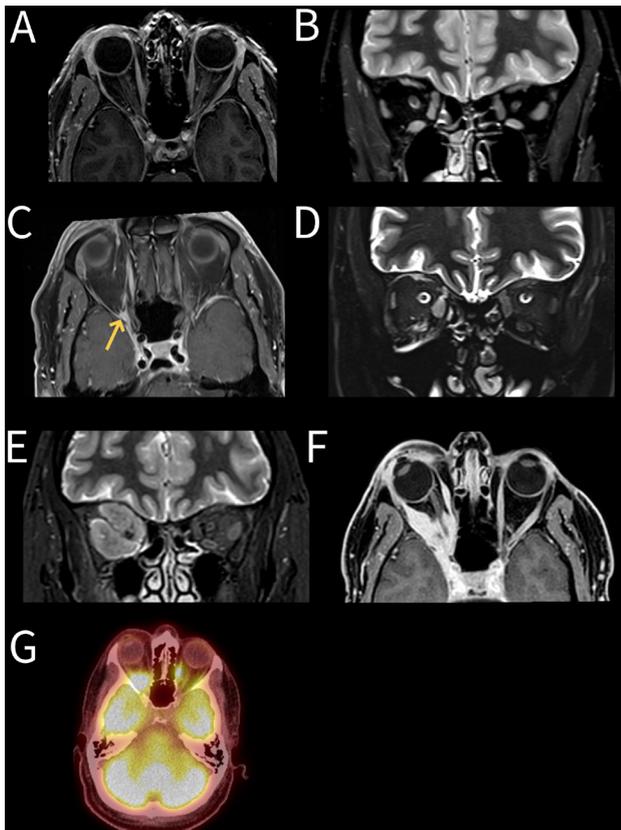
(A, B) Initial MR scan of orbits (A=axial T1-weighted postcontrast; B=coronal T2-weighted) showing no abnormality of the extraocular muscles or orbital apex. Even with the benefit of hindsight and specialist neuroradiological review, the imaging was considered normal despite the marked clinical signs. (C, D) Second MR scan of orbits (C=axial T1-weighted postcontrast; D=coronal STIR) showing swelling of the right medial and inferior recti, with subtle enhancement at the right orbital apex (arrow). On retrospective review, there is an asymmetric signal abnormality suggestive of oedema involving all the right extraocular muscles. In the context of negative investigations for inflammatory orbital pathology at this stage, such a pattern should have raised a red flag for widespread muscle denervation, which would typically be due to proximal structural pathology (ie, at the orbital apex, cavernous sinus or superior orbital fissure). (E, F) Fourth MR scan of orbits (E=coronal T2-weighted; F=axial T1-weighted postcontrast) showing dramatic progression of extraocular muscle enlargement and enhancement, together with an enhancing mass at the right orbital apex. (G) 18F-FDG PET-CT showing increased metabolic uptake corresponding to the right orbital apex mass.
